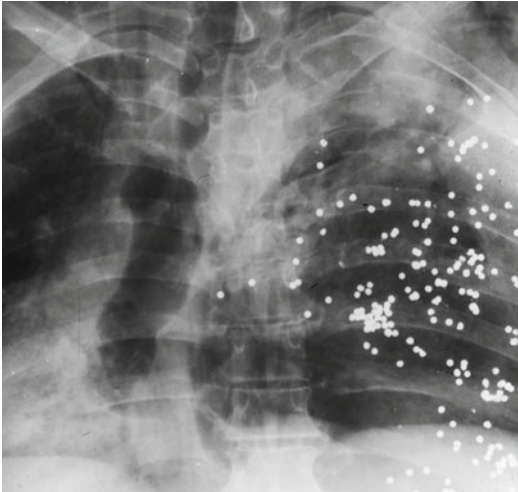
Multiple shot pellets seen on chest X-ray
